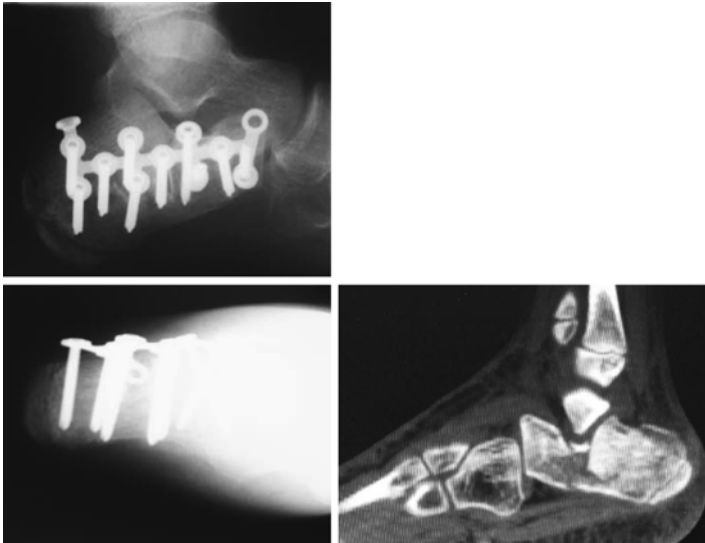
Comminuted fracture of a calcaneum in a 13 year old child – a CT scan of the injury and post operative radiographs (Reprinted with permission from Benson et al. (2009) *Children's Orthopaedics and Fractures*, Springer)
